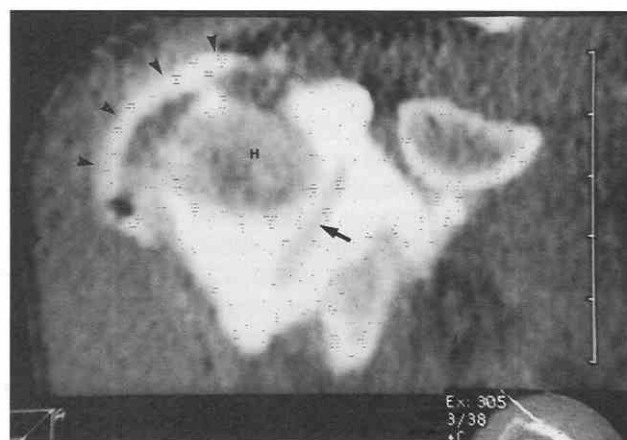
Bicipital tendon dislocation. Coronal reconstruction of an axial single-contrast CT arthrogram. The bicipital tendon (*arrow*) projects medial to the humeral head (*H*) in an intra-articular location. Contrast material extends through a gap in the supraspinatus tendon to outline the subacromial-subdeltoid bursa (*arrowheads*).
